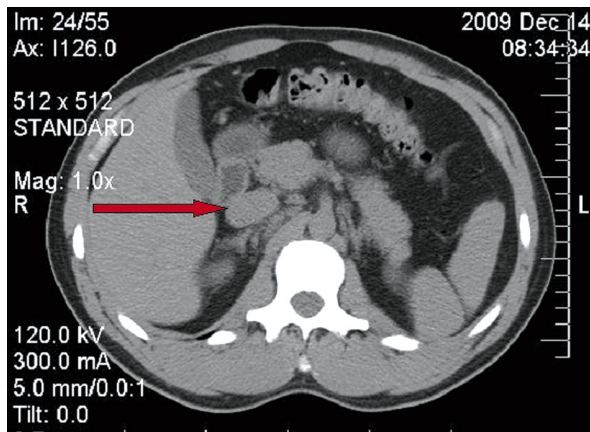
Computed tomography without contrast (5 cm regular tumour)
